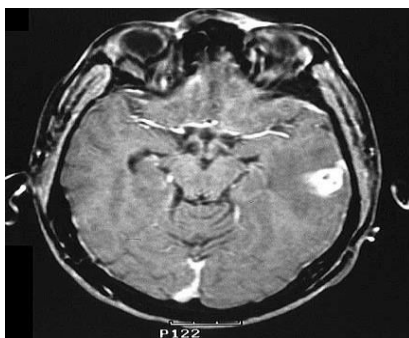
Medical Images with tampers inside ROI (a) MRI of shoulder (b) CT scan of brain (c) MRI of brain
